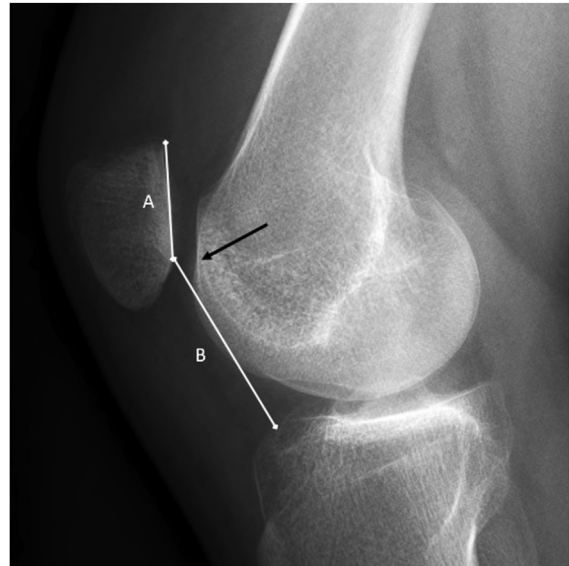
Sagittal radiograph depicting a crossing sign (black arrow). Caton-Deschamps index is equal to the magnitude of distance B divided by distance A.
